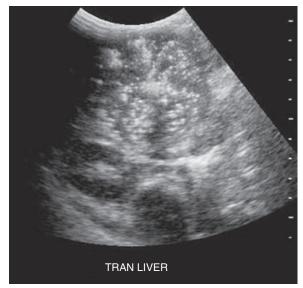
Transverse sonogram of the right upper quadrant.
